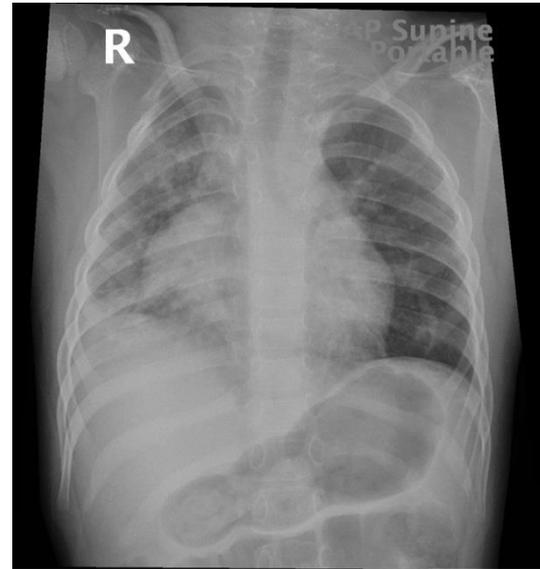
Chest X-ray showing: evidence of bilateral parahilar congestion, obliteration of the right CP angle, left CP angle was patent and the bony cage is unremarkable with mild pleural effusion on the right side. Cardiac size was not well assessed, but there may be mild cardiomegaly.
